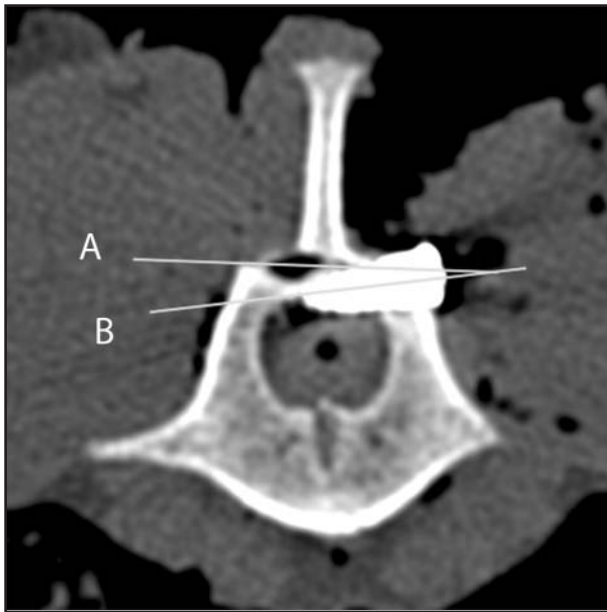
A CT image of a screw that penetrates the vertebral canal. The drill hole (line A) does not penetrate the vertebral canal and is dorsal to the tract created by insertion of the screw (line B).
